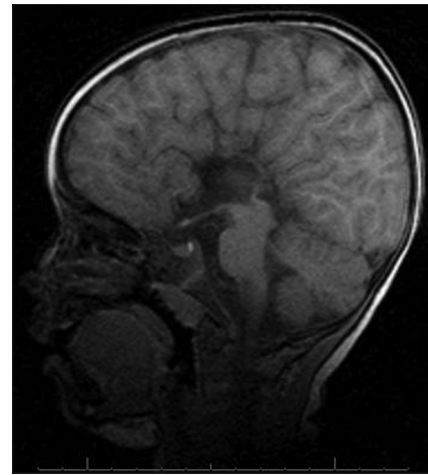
Brain magnetic resonance imaging-sagittal image show agenesis of complete corpus callosum
